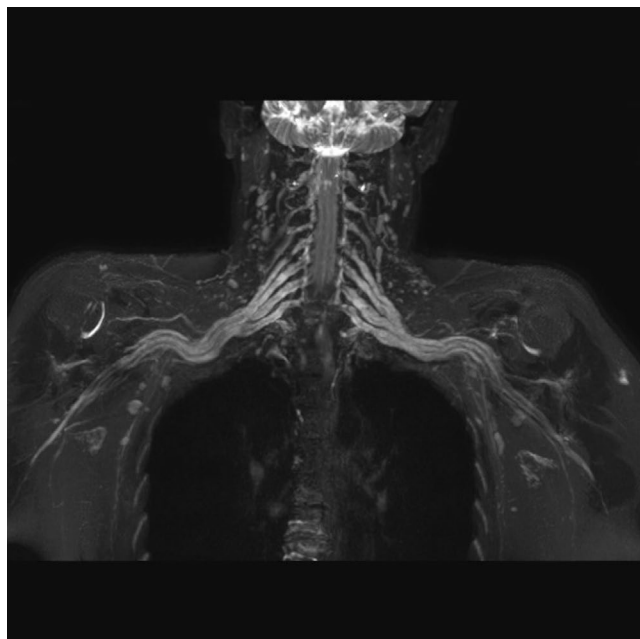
Coronal reconstructed MIP MPR MRI scan showing thickening of brachial plexus.
